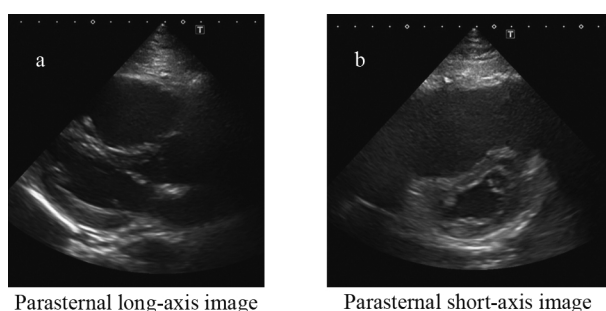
Transthoracic echocardiogram (TTE) on admission
